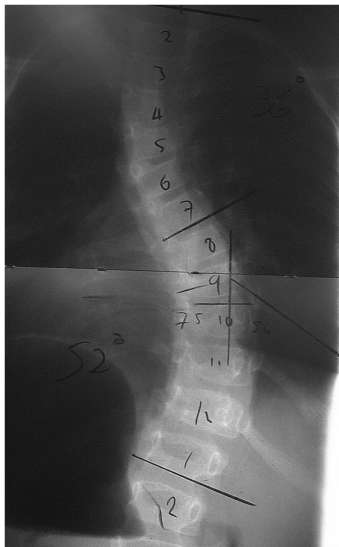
4 AP view x-ray of a 6-year-old boy with EOS and thoracic insufficiency syndrome treated with VEPTR.
